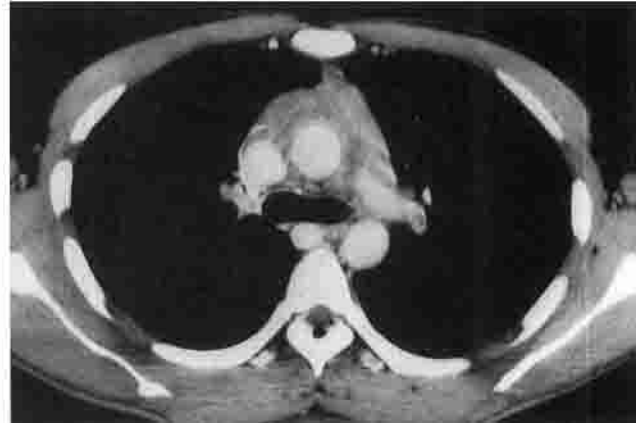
Chest CT findings at the same level of Figure 1 in the same patient after preoperative irradiation. Tumor prominently shrank, and the SVC is recanalized.
